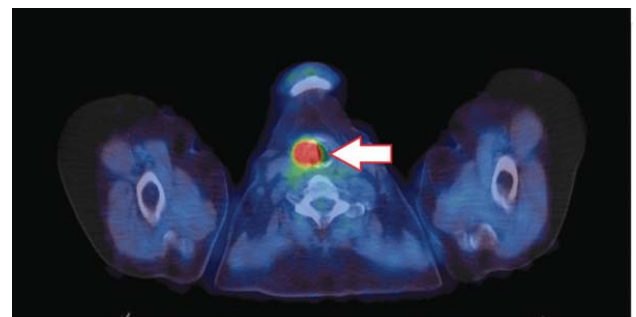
Axial fused PET/CT from the neck at level of vocal cords shows intense right vocal cord uptake (arrow)
